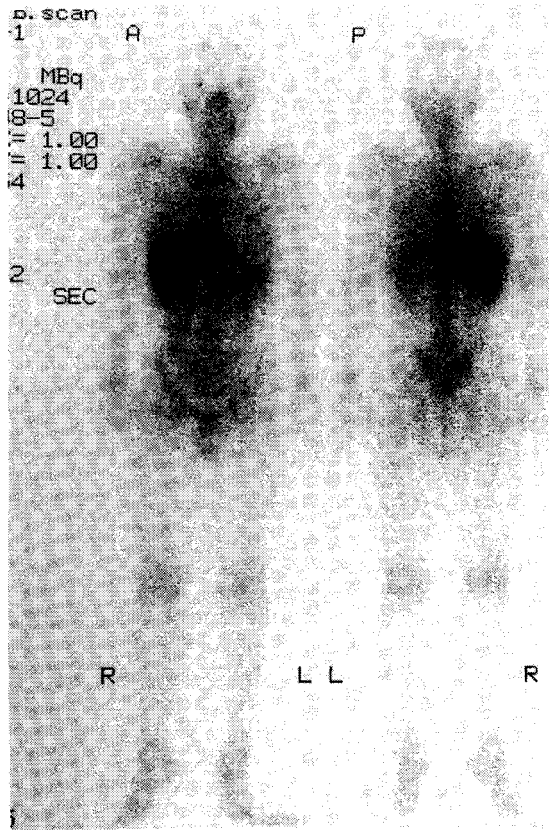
Gallium scintigraphy after Keishi-ni-eppi-itto-ka-ryojuetsubu therapy, showing no increased uptake in the joints throughout the whole body.
